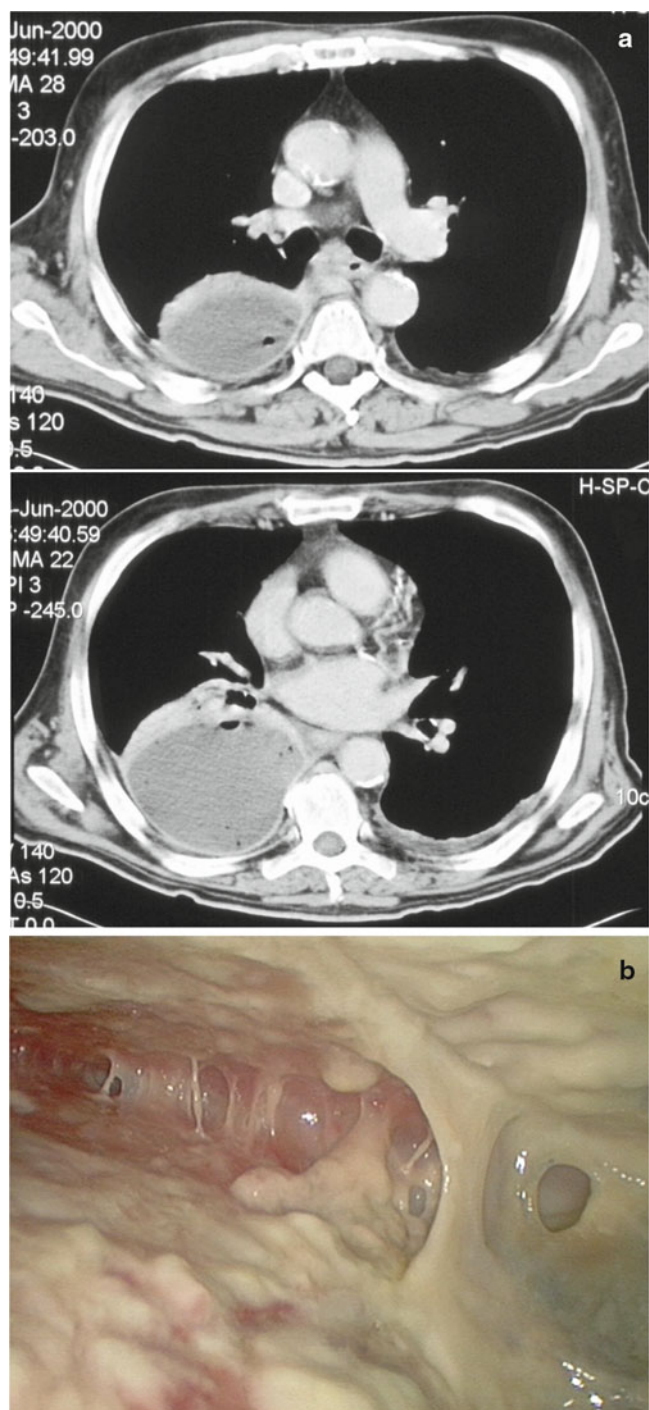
Empyema. (a) Radiologic (CT) and (b) intraoperative appearance, respectively
